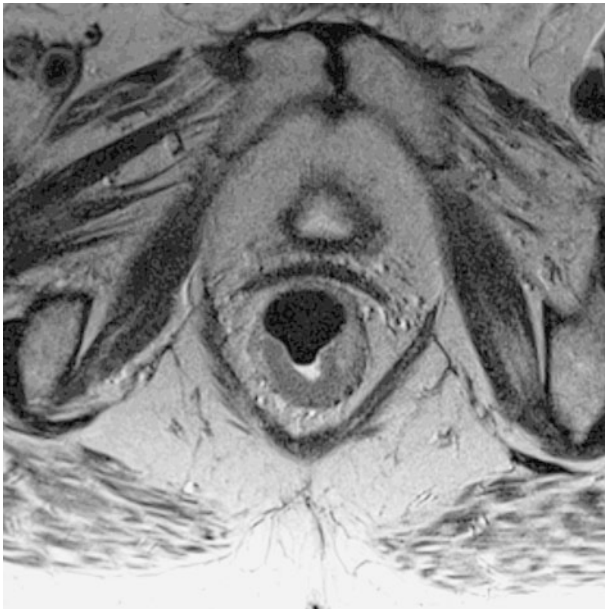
Axial T2-weighted image. Ulcerating tumor in an axial view showing bowl like appearance with central depression and raised, rolled edges
